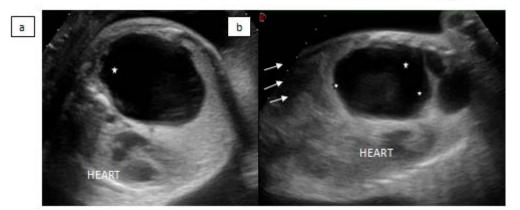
obstetric ultrasound performed at 33 weeks in axial (a) and coronal (b) section: Right pulmonary cystic masses (star) driving the heart towards the contralateral side and lowering the homolateral diaphragmatic dome (arrows).
